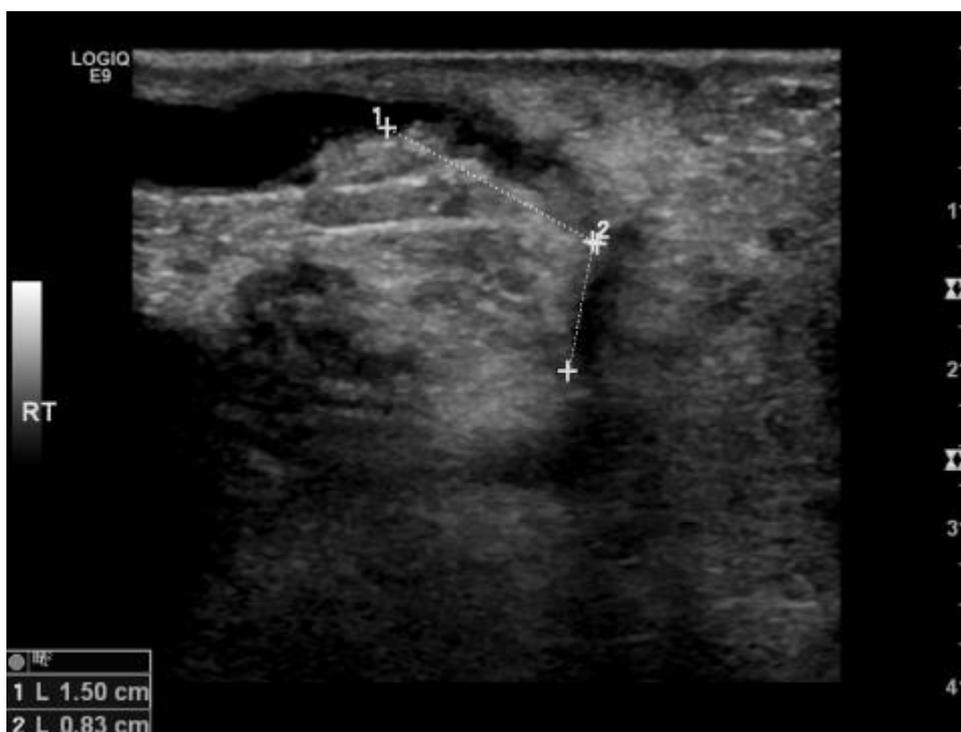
Stenosis of the fistula outflow vein demonstrated just past the anastomosis on B-mode ultrasound.
